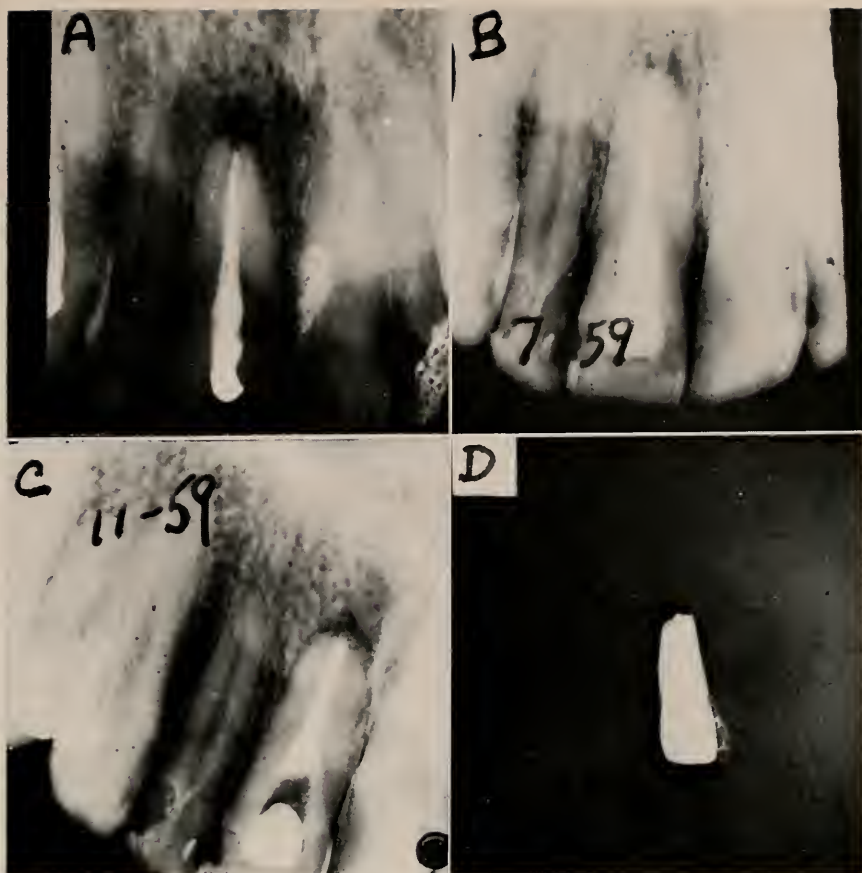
Case 4. Apical resorption. A. Diagnostic x-ray showing incompletely filled canal, April, 1958. B. X-ray showing retreatment in July, 1959. C. X-ray directly following apical curettage in November, 1959. Patient was still complaining of pain. D. Photograph of extracted tooth four months after curettage. Patient still complained of pain and requested extraction. Marked apical resorption is exhibited on photograph of extracted tooth.
